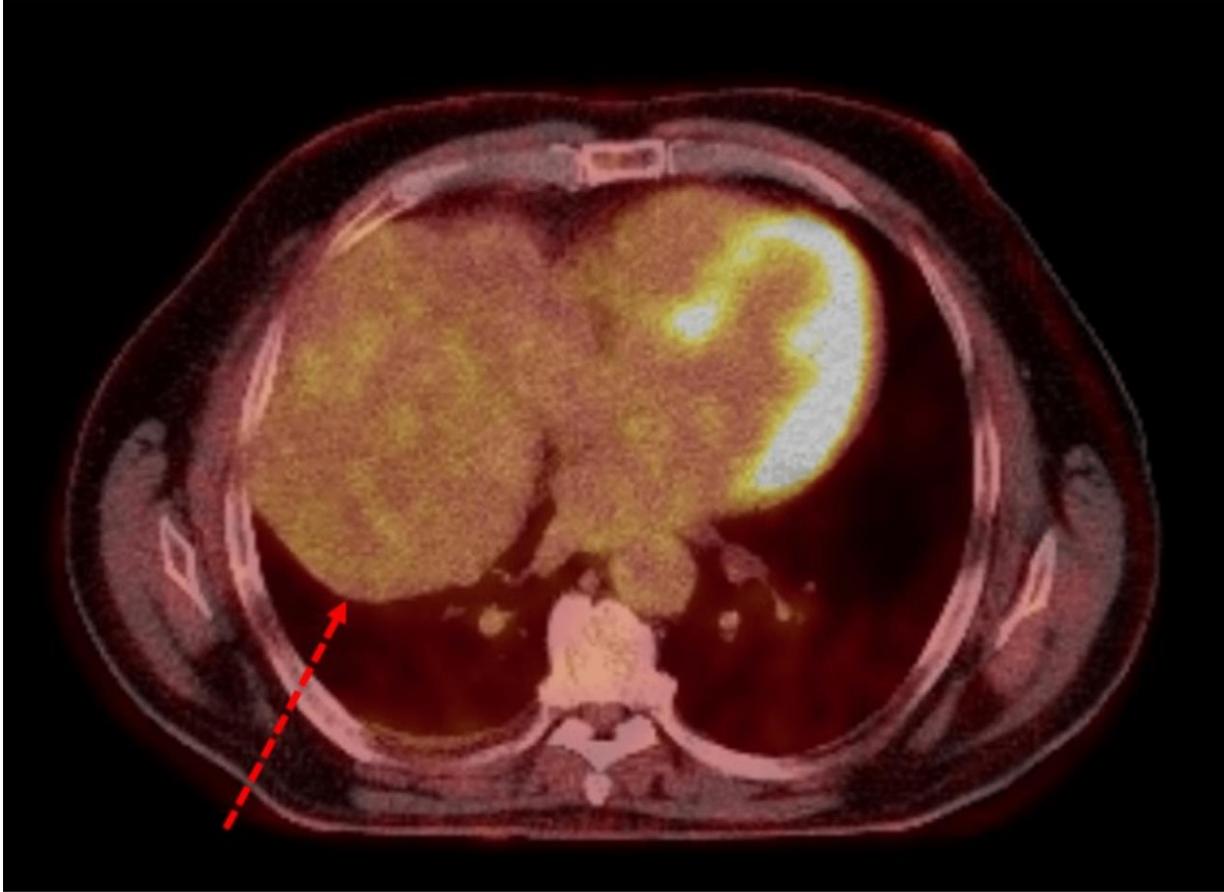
Positron-emission tomography (PET) images demonstrating a large mass, measuring approximately 25 cm x 15 cm, occupying the entire right hemithorax (black arrow). The maximum standardised uptake value (SUV max) was 2.5, similar to the rest of the mediastinal uptake. No fluorodeoxyglucose (FDG)-avid mediastinal or hilar lymph nodes were present. Panel A shows a coronal view.
